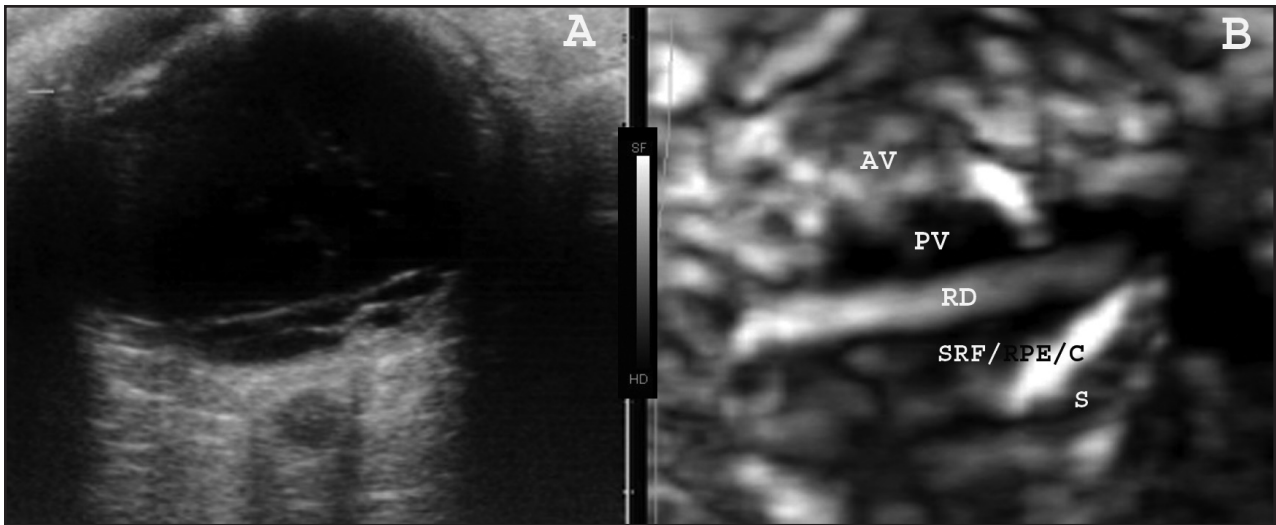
Grayscale ultrasound transverse elastographic image of an eye with chronic retinal detachment (B). The detached retina (RD) appears more elastic (with higher luminosity), compared with the posterior vitreous cavity (PV) and long-standing (viscous) subretinal fluid (SRF). The complex of retinal pigment epithelium (RPE) and choroid (C) also appears with a high luminosity (elastic), whereas the anterior vitreous cavity (AV) appears with intermediate luminosity. On the contrary, the sclera (S) is shown with a low luminosity (inelastic). A corresponding B-scan image is also presented (A), whereas the gray scale from white (more elastic) to black (less elastic) is shown between A and B.
